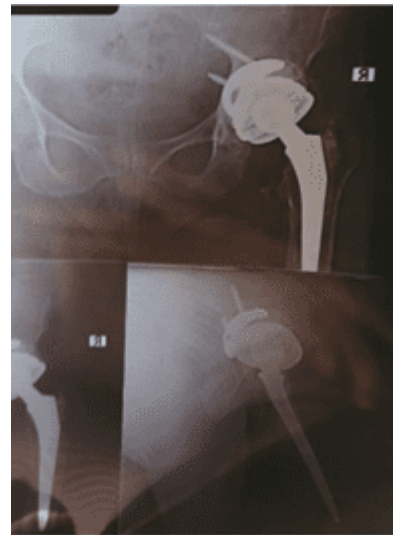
Follow up X-ray after 14 months
